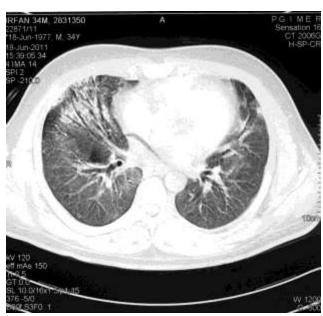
(b): Chest CT scan showing bilateral consolidation
